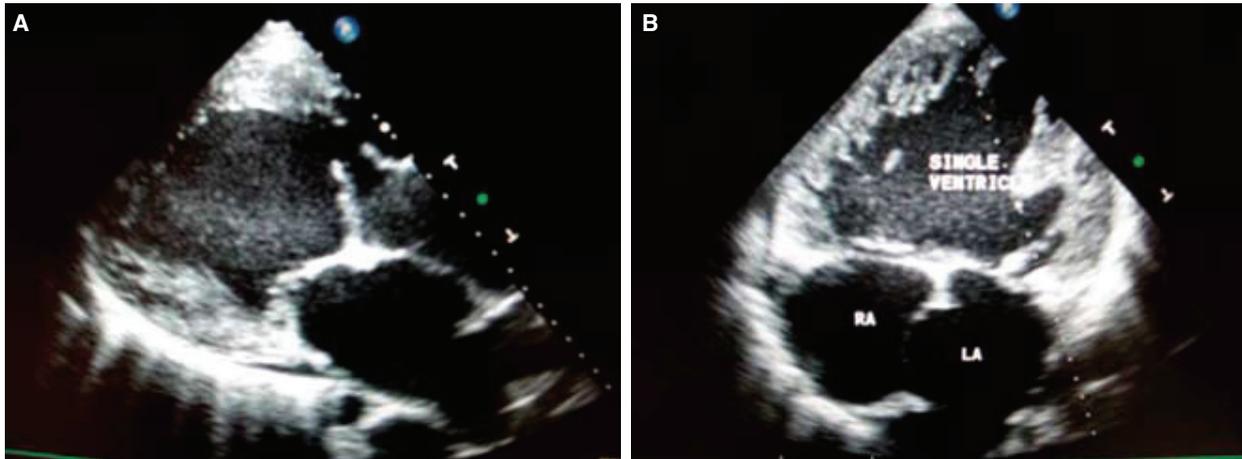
(A) Parasternal long-axis view of two-dimensional echocardiography showing the interventricular septal defect. (B) Apical four-chamber view of two-dimensional echocardiography showing the interventricular septal defect and deep intertrabecular recesses.
